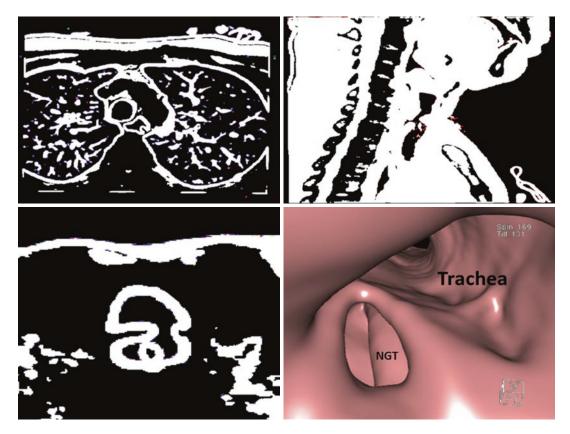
Patient with TEF diagnosed after nondiagnostic several contrast studies; CT was carried out using modified Valsalva maneuver with nice demonstration of the fistula tract
